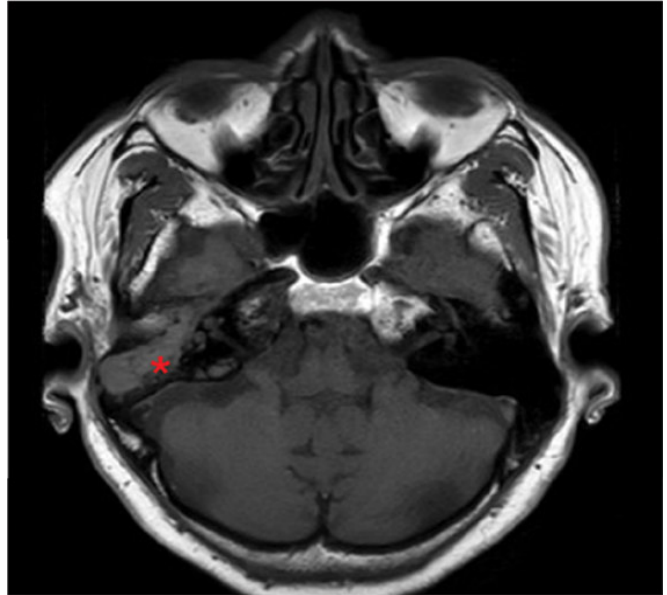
T1W MRI : Intermediate intensity soft tissue signal in Right middle ear cleft.
